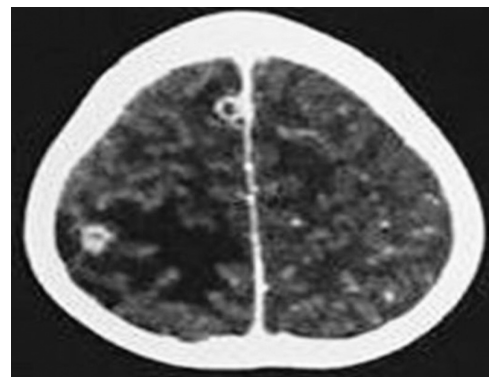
Contrast CT scan of brain showing well defined peripherally enhancing lesion in the right high parietal (near the falx) and right high frontal region. There is hyperdense scolex within and perilesional edema, suggestive of cerebral neurocysticercosis/NCC (colloid-vesicular stage).
